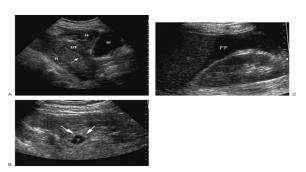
Image from Delani, D Levine: Ectopic pregnancy: A review Ultrasound Q: 20: 105, 2004
